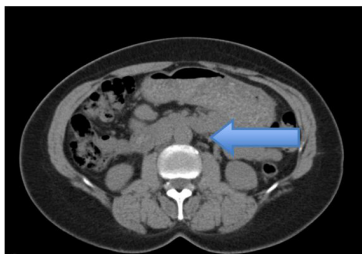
August 2013 CT Scan Abdomen/Pelvis, no contrast.
